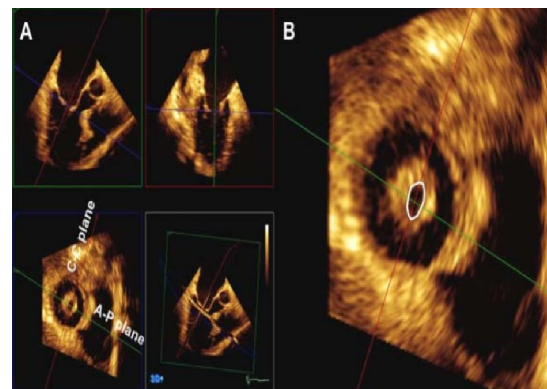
MVA planimetric measurement in parasternal short axis view.
